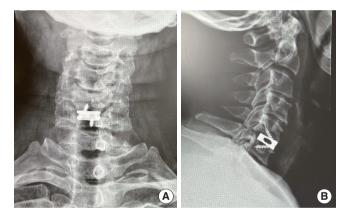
Postoperative coronal (A) and lateral (B) standing x-ray films of a single-level full-endoscopic endoscopic anterior cervical decompression and fusion.
